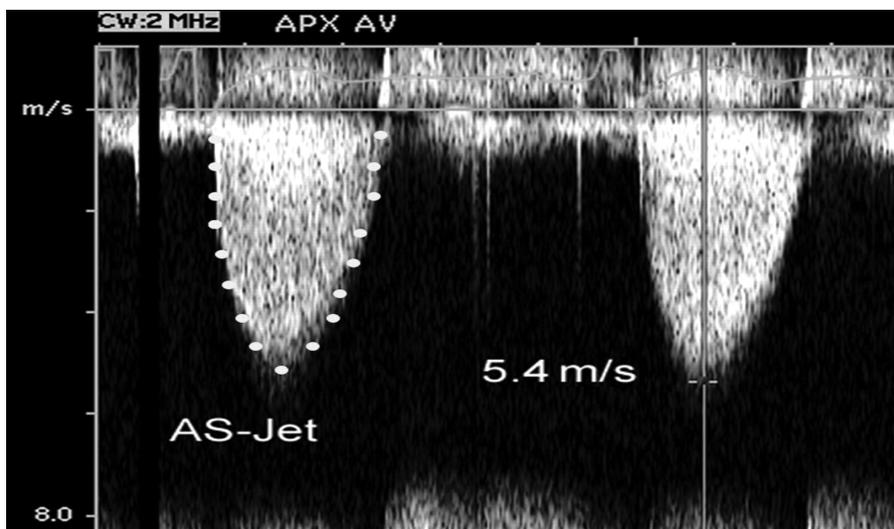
Continuous-wave Doppler of severe aortic stenosis jet showing measurement of maximum velocity and tracing of the velocity curve to calculate mean pressure gradient.
